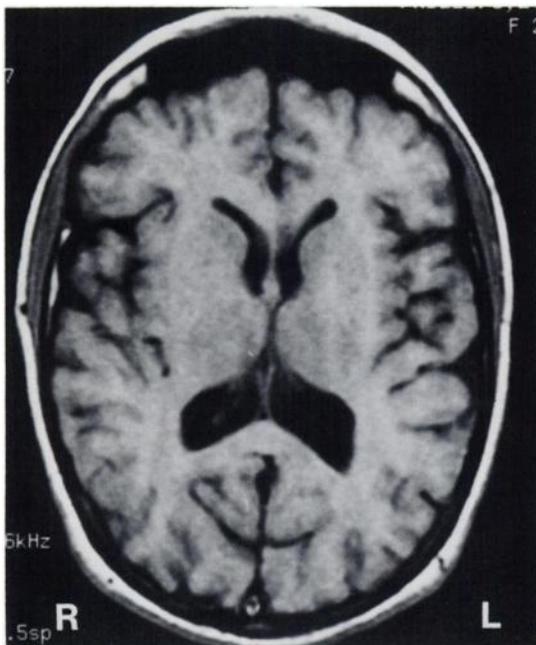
The MRI scan shows mild cerebral atrophy, but no abnormalities of the thalami or caudate head nuclei.
